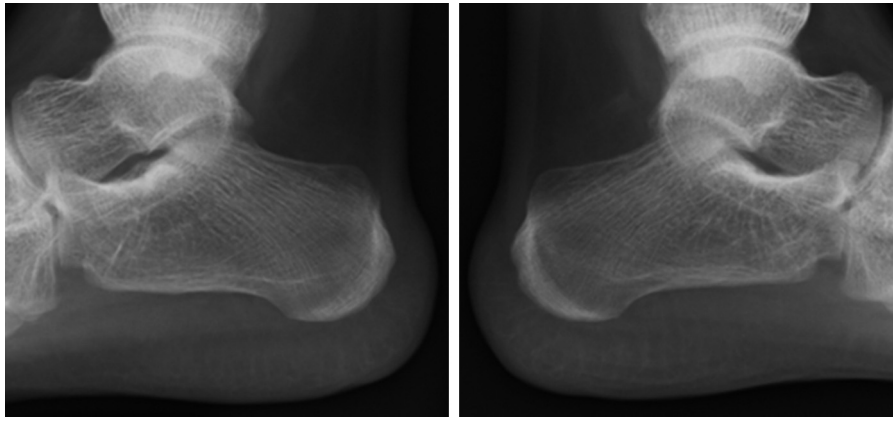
Right and left lateral calcaneal radiographs.
